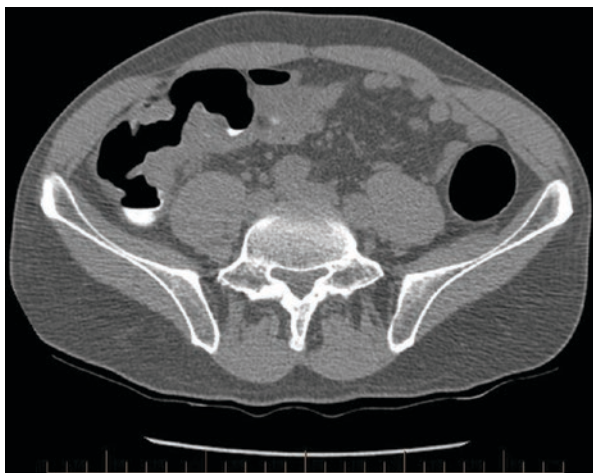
2D (axial) and 3D (“fly-through”) CT data sets for CTC
